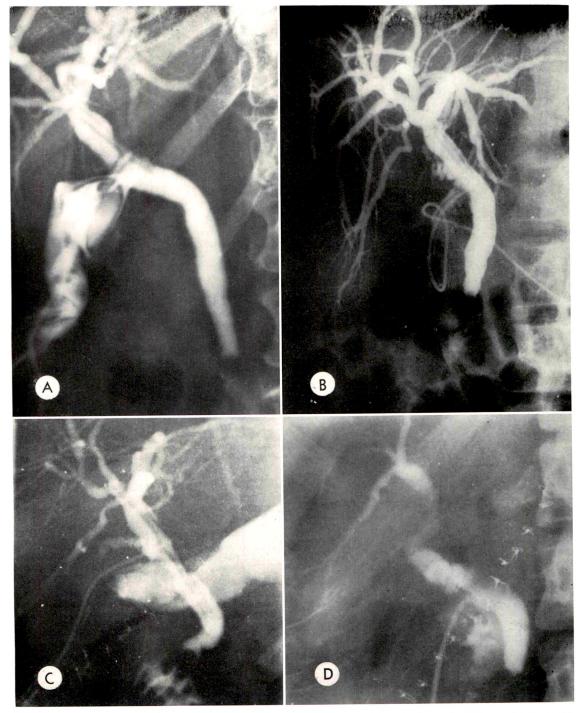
Four examples of obstruction in the distal end of the common duct having a similar roentgenographic appearance, which choledochoscopy attempts to differentiate. ( $\mathcal{A}$ ) Polyp; ( $\mathcal{B}$ ) calculus; ( $\mathcal{C}$  and  $\mathcal{D}$ ) spasm.
